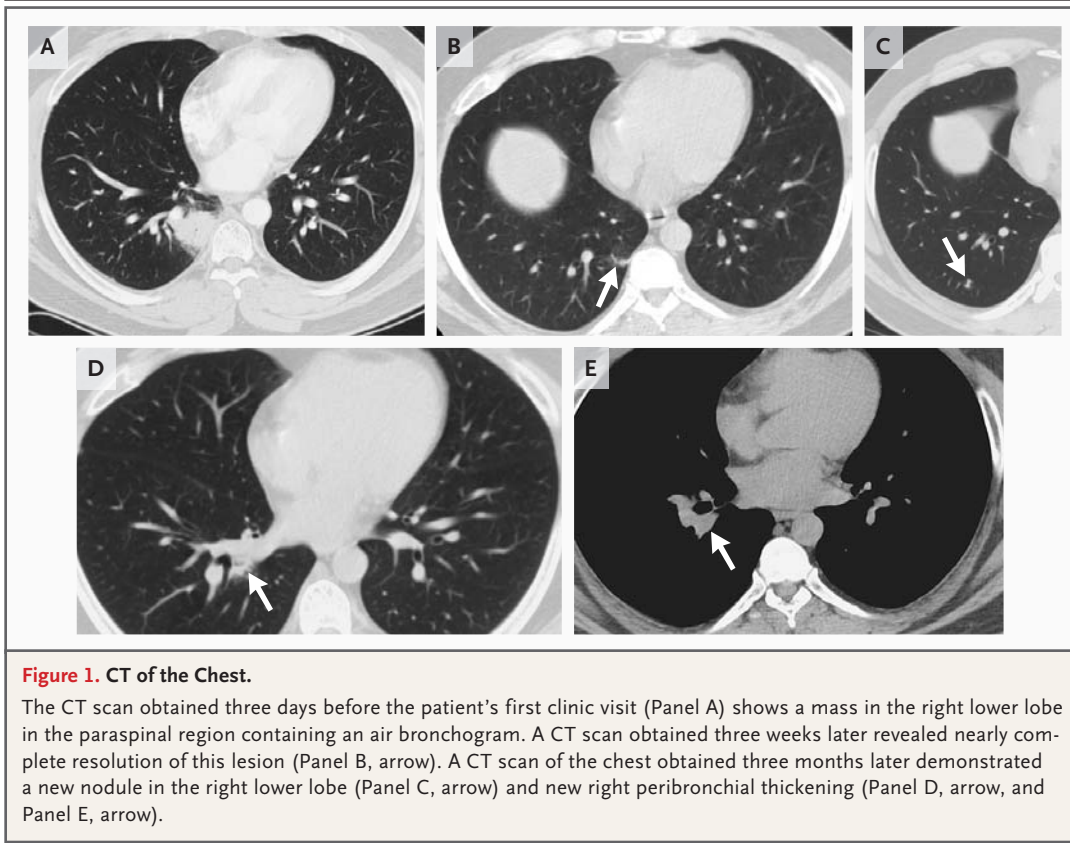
CT of the Chest.
